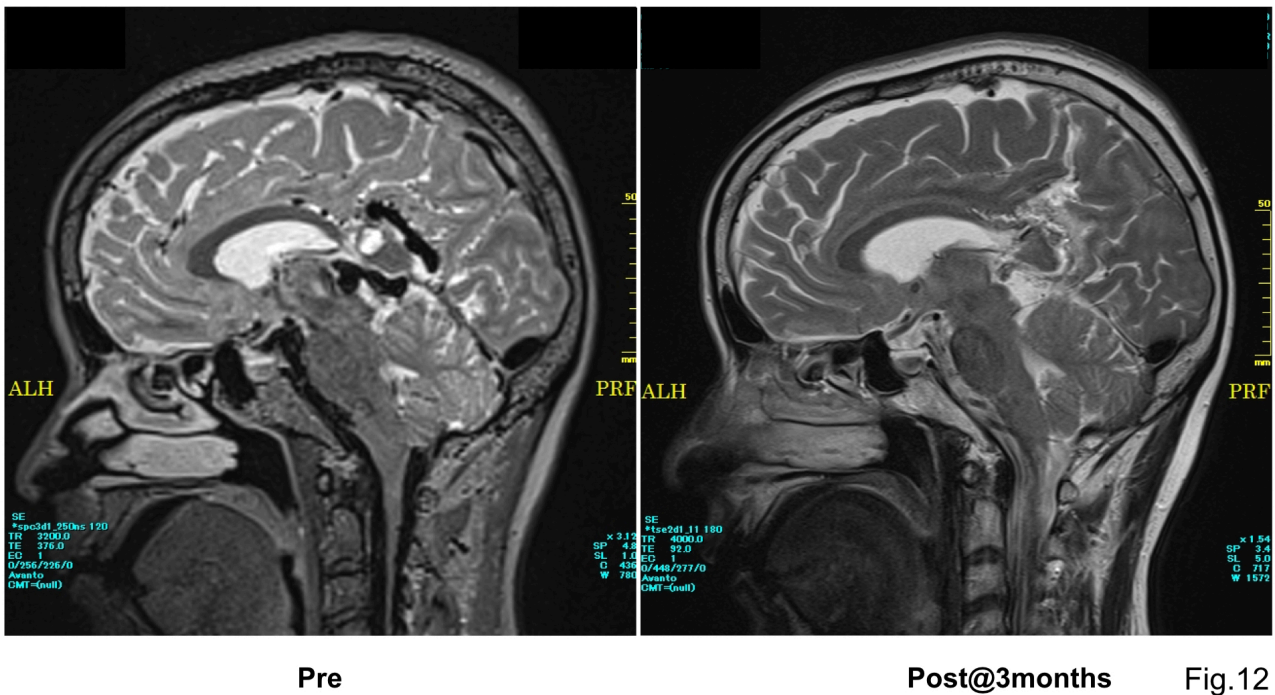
MRI T2 weighted image of pre and post embolization. Although the isthmus part of the cingulate gyrus was damaged because of the initial hemorrhage, the cognitive function of the patient improved significantly.
